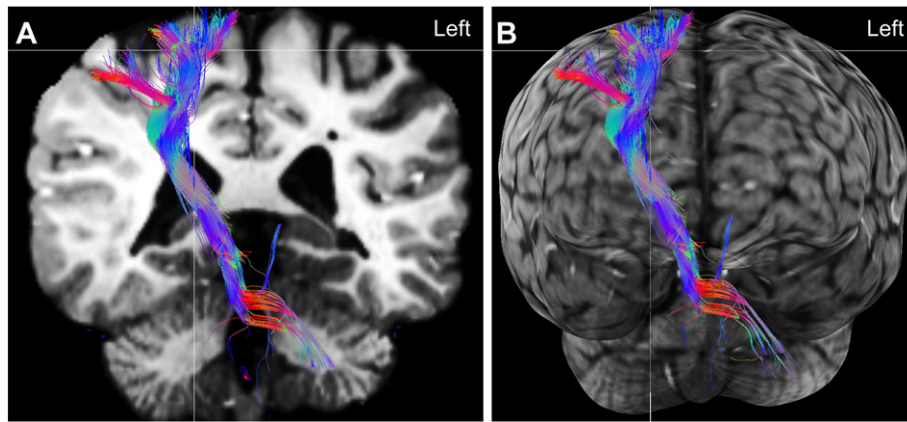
(A) 3D DTI tractography of the corticospinal tract (colored image) superimposed on a 2D coronal slice of the T1-weighted magnetization-prepared rapid gradient-echo (MPRAGE, black and white image) and (B) the same tractography projected onto a cortical surface rendering, to better depict its trajectory.
